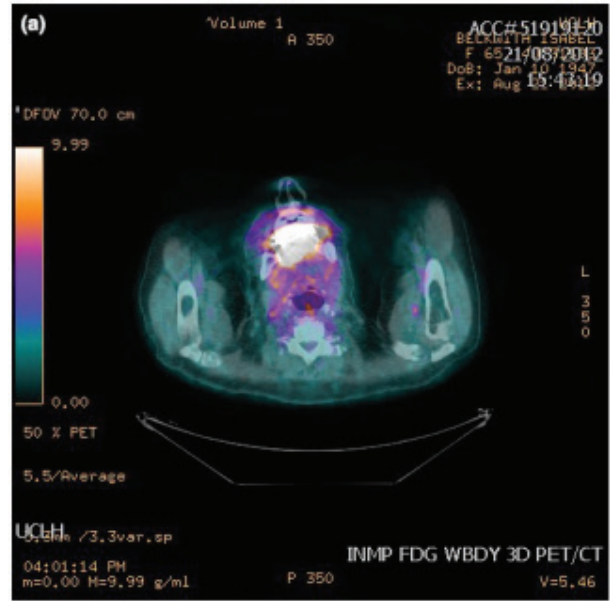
Image of assessment of metastasis using 3D PET/CT
